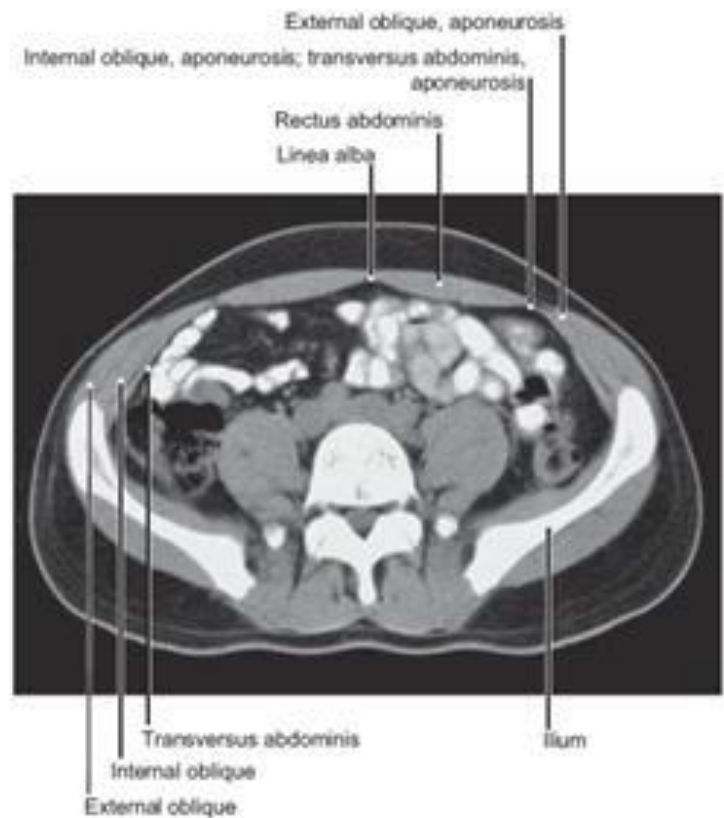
CT of the Muscles of the Abdomen at the Level of the Fifth Lumbar Vertebra
